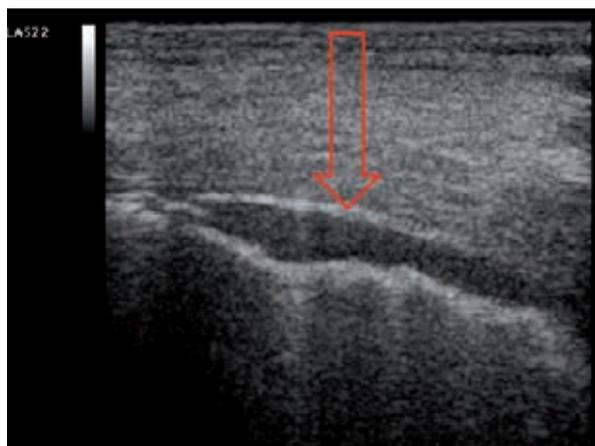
Ultrasonographic pattern of parenchymal lung consolidation; hypoechoic subpleural focal images with or without pleural line gap, either isolated or multiple, appear as hypoechoic pleural-based focal images allowing ultrasound transmission, from which B-line-like artifacts arise, with confluent consolidations (“hepatization”).
